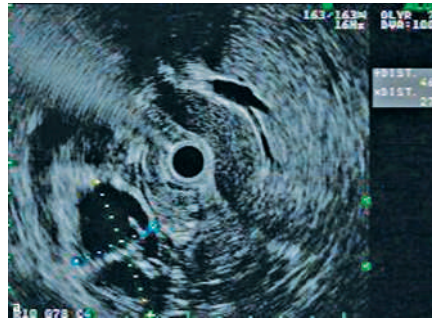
Radial endoscopic ultrasound images from patient 1 (a) and patient 2 (b), showing measurements of the septated cyst (cross-hairs).
